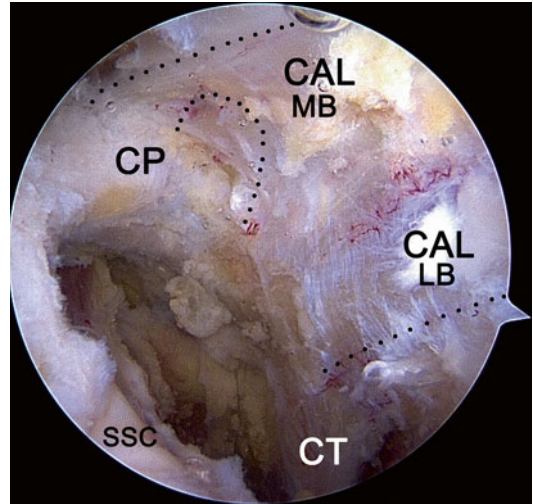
The anatomy of the coracoacromial ligament (CAL), MB medial band, LB lateral band, CP coracoid process, CT conjoint tendon
